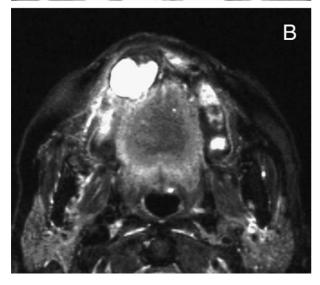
Diagnostic images for central hemangioma in the maxilla of a 74-year-old female. (A) CT image showing an intraosseous mass lesion with scalloping margins irregularly enhanced with contrastive media. (B) MR image showing high T2-weighed signals in the intraosseous as well as exophytic parts.
